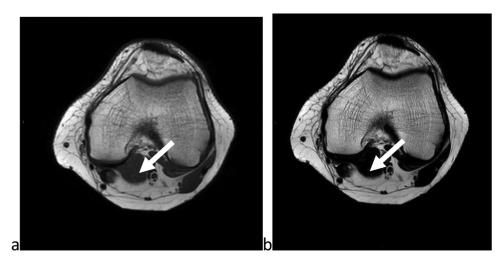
Magnetic Resonance (MRI) of the left knee. Axial TSE T1-weighted (w) image (a) and axial TSE T2-w (b) MRI images, demonstrate the accessory popliteus muscle (arrow).
